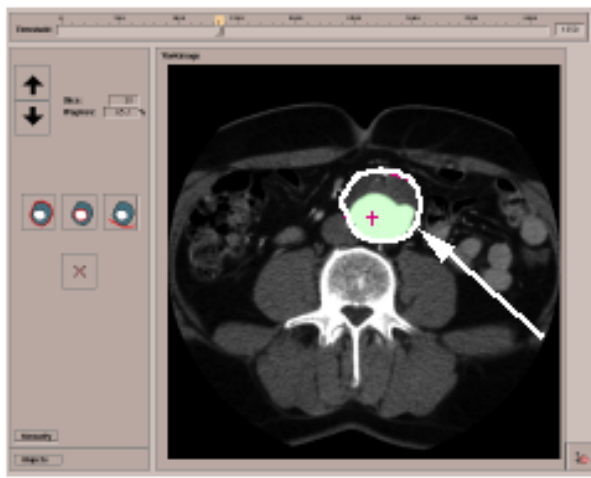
Automatic segmentation of the lumen from the CT data
